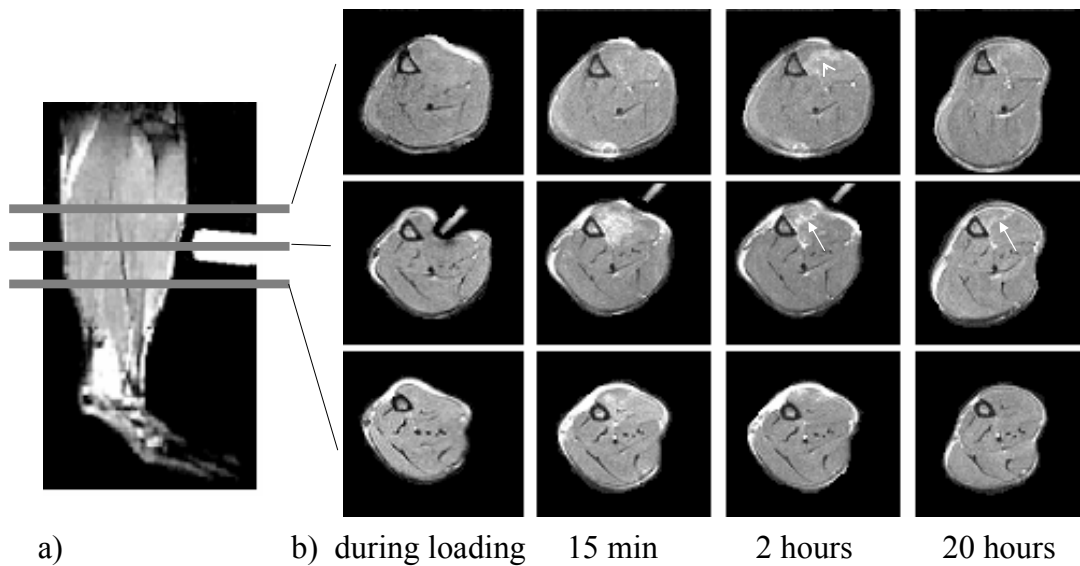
a) Sagittal slice of the lower limb showing the position of the indenter relative to the TA. b) Transversal T2-weighted images at three different positions, as indicated in left image. The extent of indentation is shown in the first column, while images taken 15 min, 2 hours and 20 hours after unloading are shown on the right side. The different shape of the leg in the last column was caused by differences in casting between the first and second day. The high values at the outer layer of the leg are caused by the skin layer.
